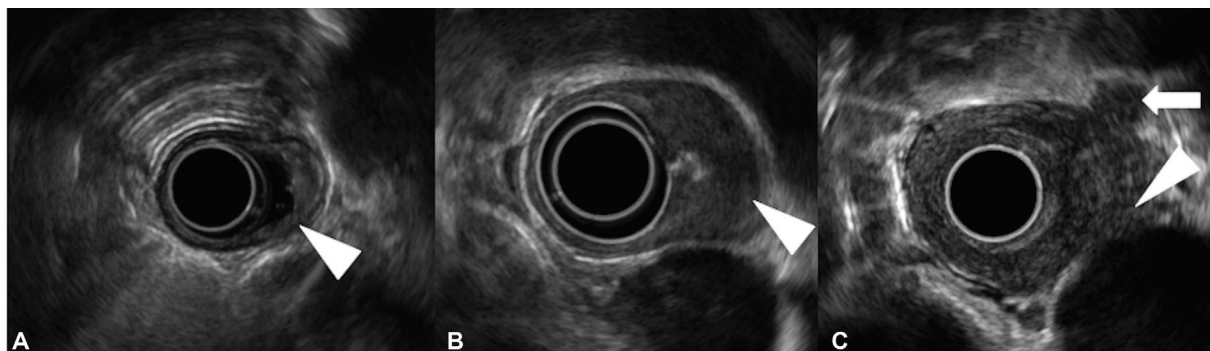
Staging of esophageal cancer on endoscopic ultrasonography. (A) T1 tumor invading the submucosa (arrowhead). (B) T2 tumor invading the muscularis propria (arrowhead). (C) T4 tumor involving the aorta (arrowhead). A malignant regional lymph node is also seen (arrow).
